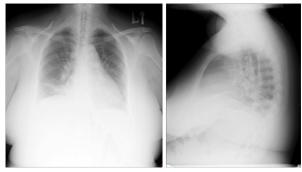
Chest radiography showing left hilar lymphadenopathy with right lung low zone opacity.
